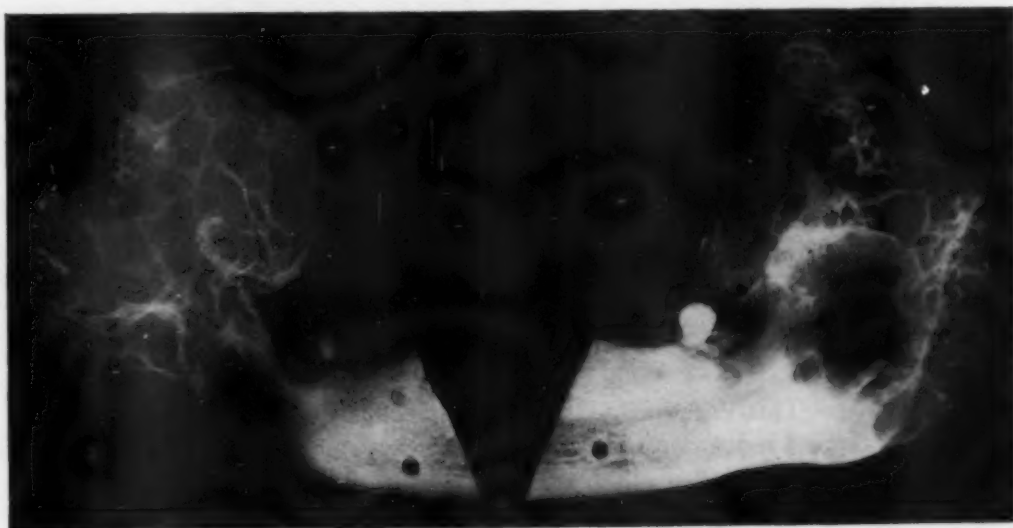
Case 3. Radiograph of the resected portion of the mandible of the ameloblastoma. (Neg. 68186.)
